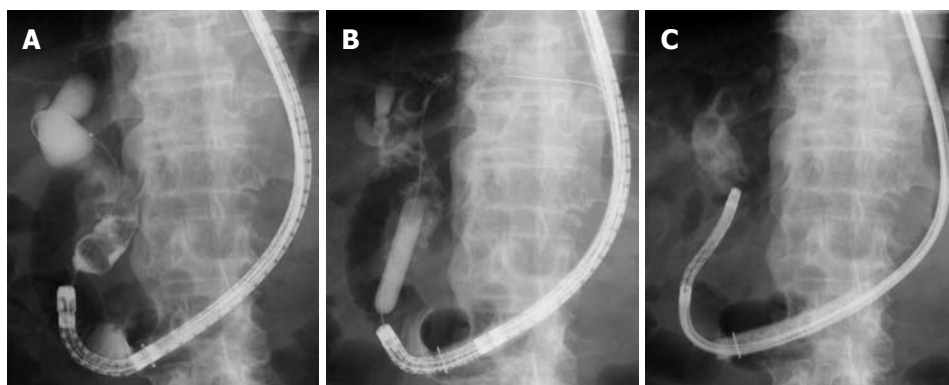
X-ray images. A: Cholangiography revealed a dilated bile duct and multiple stones piled up at the lower to middle part of the bile duct; B: Papillary dilation using a large balloon catheter; C: An ultra-slim gastroscope was introduced directly into the bile duct.
